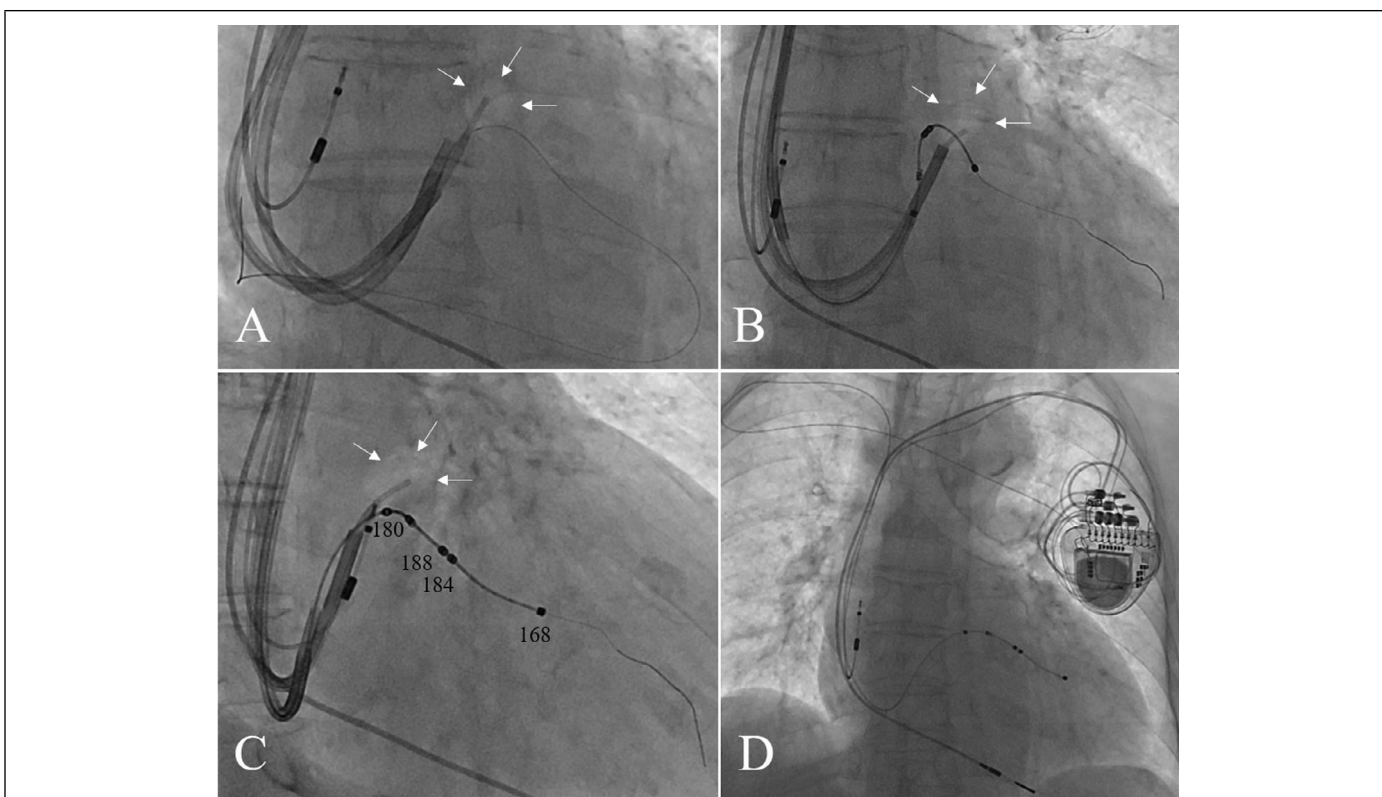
(A) Distal occlusion of the coronary sinus by the balloon catheter. The inflated balloon is marked by white arrows. (B) Lead insertion into the target vein using the balloon occlusion technique. The inflated balloon is marked by white arrows. (C) Fixation of the left ventricular (LV) lead (Medtronic 4798 active fixation quadripolar single-canted lead) to the target vein at the basal portion of the left ventricle (in right posterior oblique projection). The numbers displayed near the electrodes indicate the time interval (msec) from right ventricular pacing to LV sensing at each electrode of the LV lead. The inflated balloon is marked by white arrows. (D) Chest X-ray after implantation (in anterior-posterior projection).
